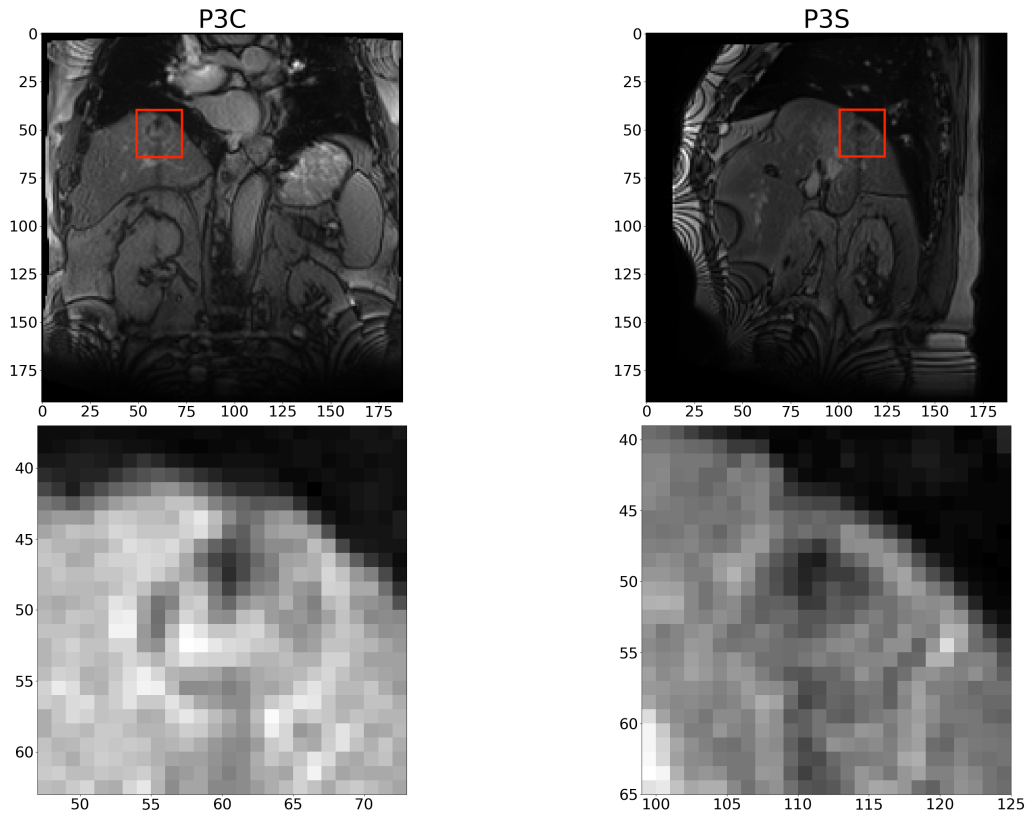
MRI images of P3 and MRI images zoomed on the tumor.
